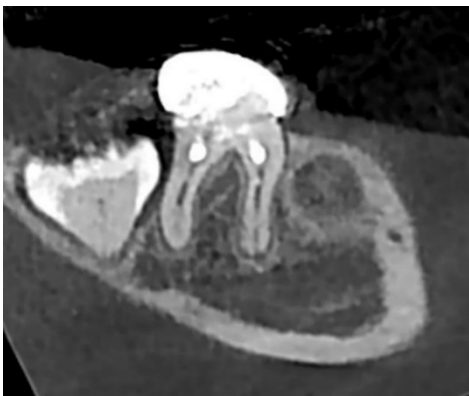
One year follow-up CBCT
